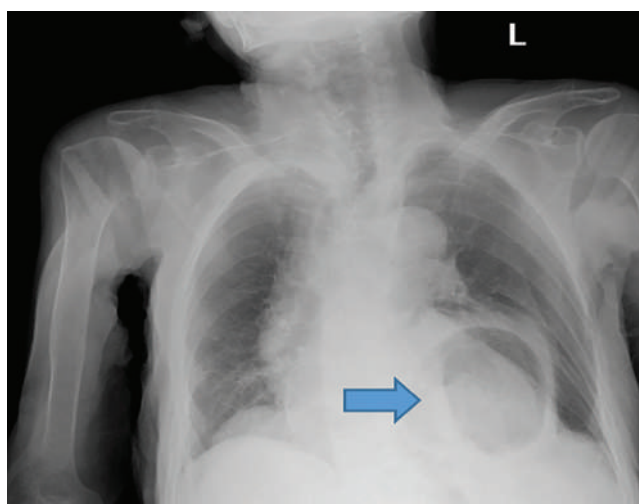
Chest X-ray showing a retrocardiac air-fluid level consistent with a hiatal hernia.
